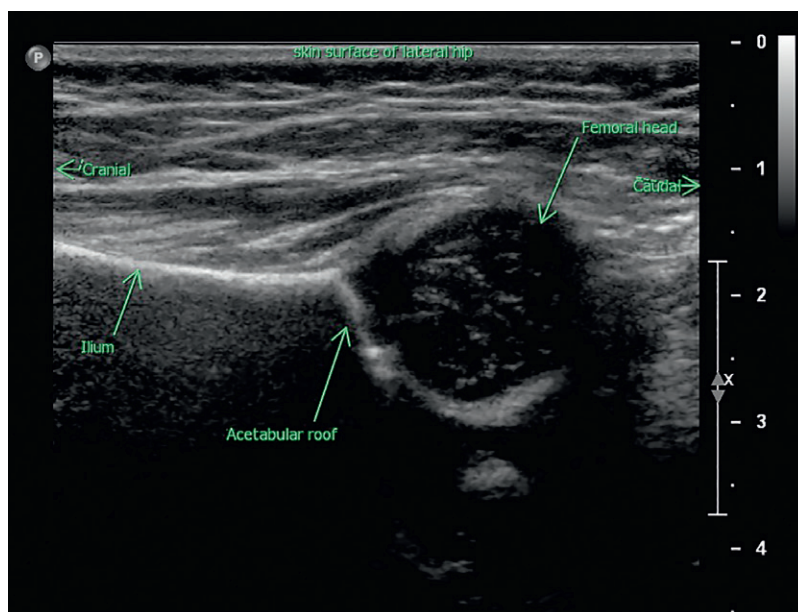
Infant hip ultrasound
